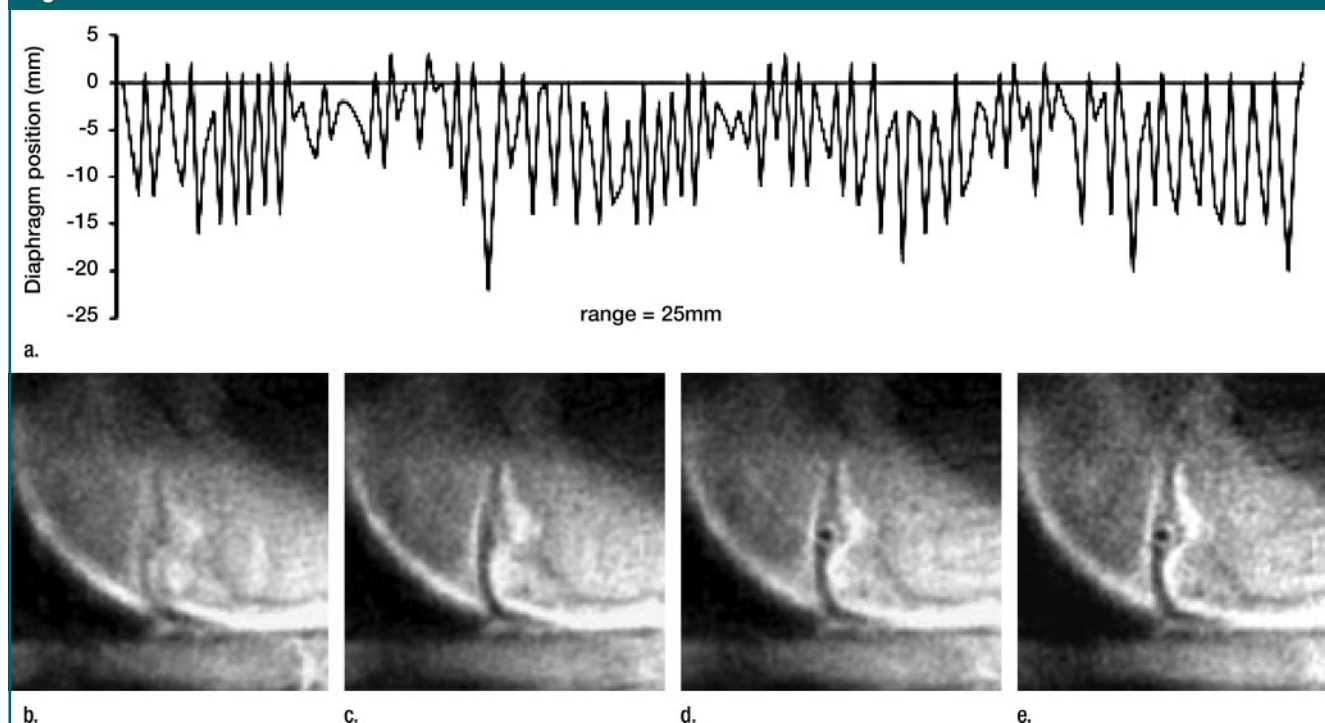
(a) Diaphragm trace and (b–e) dark-blood coronary MR images in a healthy volunteer acquired over full range of respiratory motion (b) with no motion correction and (c–e) after beat-to-beat correction of (c) in-plane motion in horizontal direction, (d) in-plane motion in horizontal and vertical directions, and (e) both in- and through-plane motion. (a) Diaphragm trace was monitored with a conventional right hemidiaphragmatic navigator throughout the acquisition. (Adapted and reprinted, with permission, from reference 161.)
